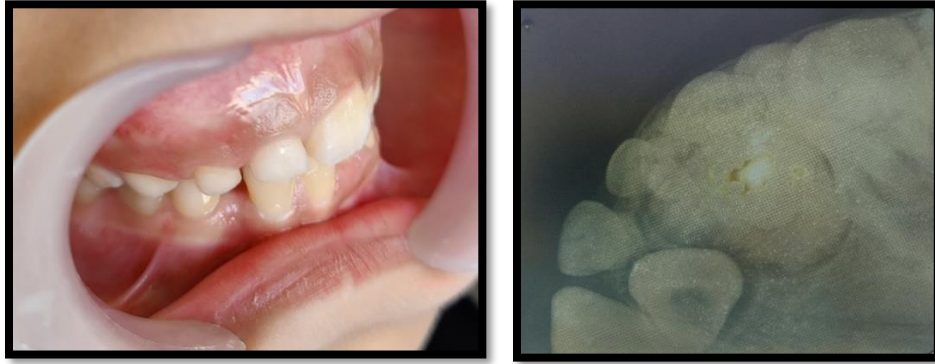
Pre operative clinical and radiographic picture
